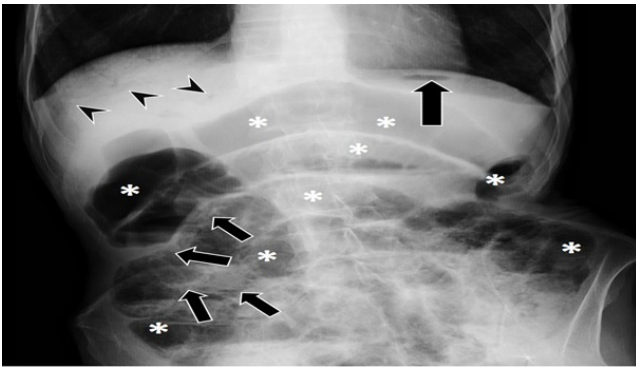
Direct abdominal X-ray image of the case. In all bowel loops, diffuse gas distension is noted (asterisks). Pneumatosis intestinalis in the intestinal walls is more prominent in small bowel loops, especially in the right lower quadrant (small arrows). The free air image in the subdiaphragmatic area on the left suggests perforation (large arrow). In addition, linear lucent areas of the liver are compatible with portal venous gas (arrowheads).
